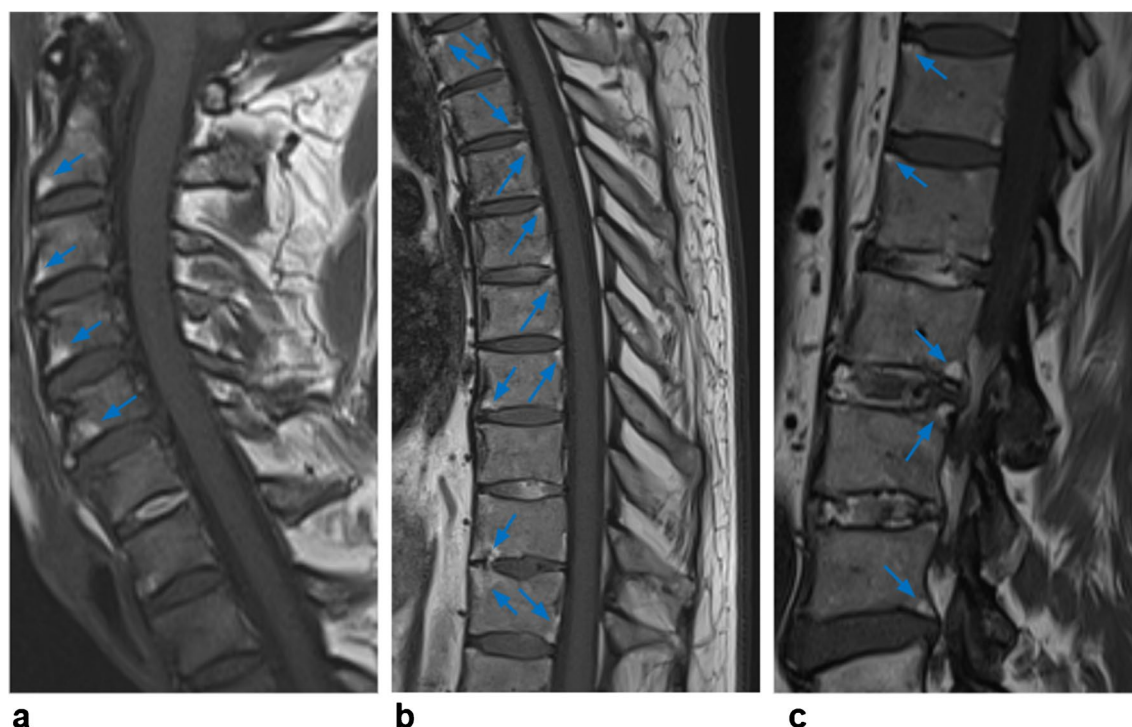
A 60-year-old man with ankylosing spondylitis. a, b, c Sagittal T1-weighted MR images of the cervical (a), thoracic (b), and lumbar (c) spines reveal high signal intensity (arrows) in multiple vertebral corners, consistent with corner fat lesions
